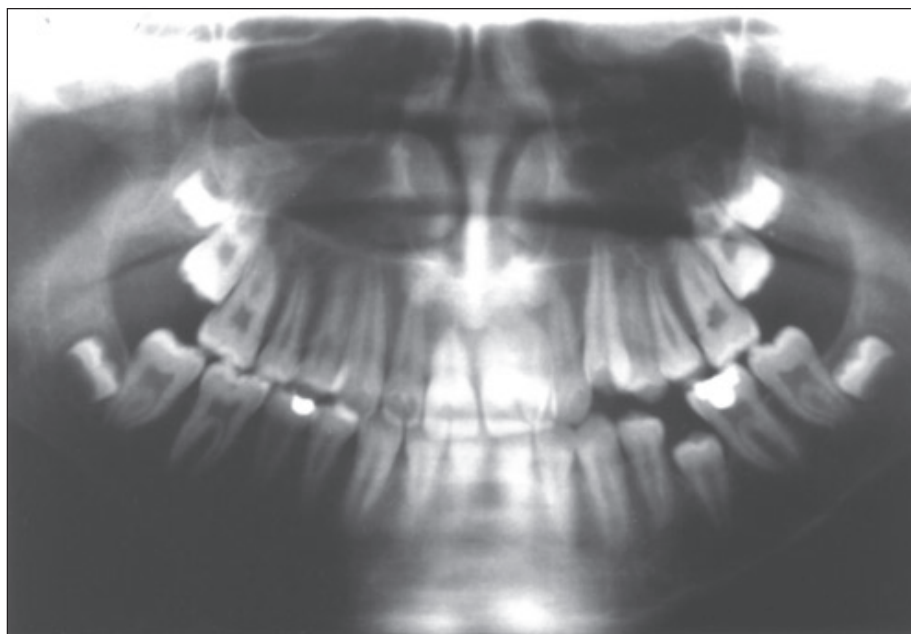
Panoramic radiograph of case 1 before treatment.
